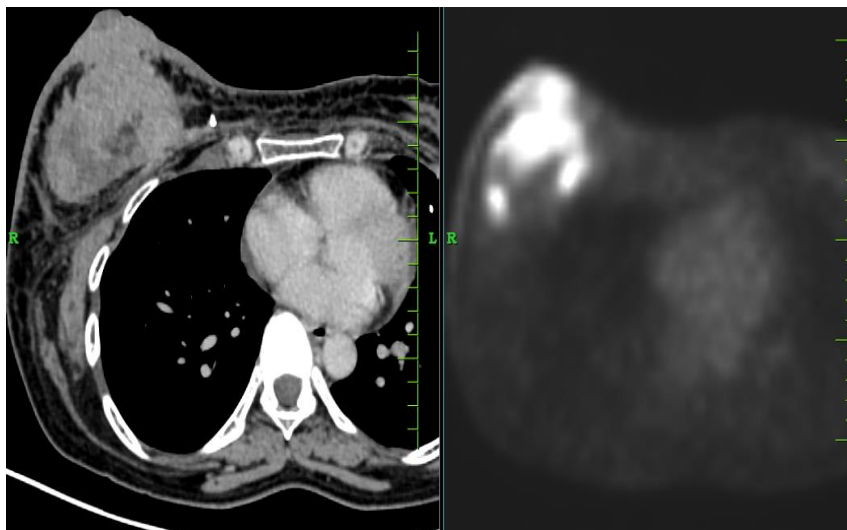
18F-FDG PET/CT demonstrating a metabolically active right breast mass. Increased FDG uptake is seen within a large, heterogeneously enhancing soft-tissue-density mass in the right breast involving the nipple–areolar complex, measuring approximately $8.9 \times 5.2 \times 8.5$ cm, with a SUVmax of 19.7. Posteriorly, the lesion closely abuts the pectoralis major muscle with loss of the intervening fat plane. The marked metabolic activity, large size, heterogeneous enhancement, and local involvement are consistent with the known malignant breast pathology.
